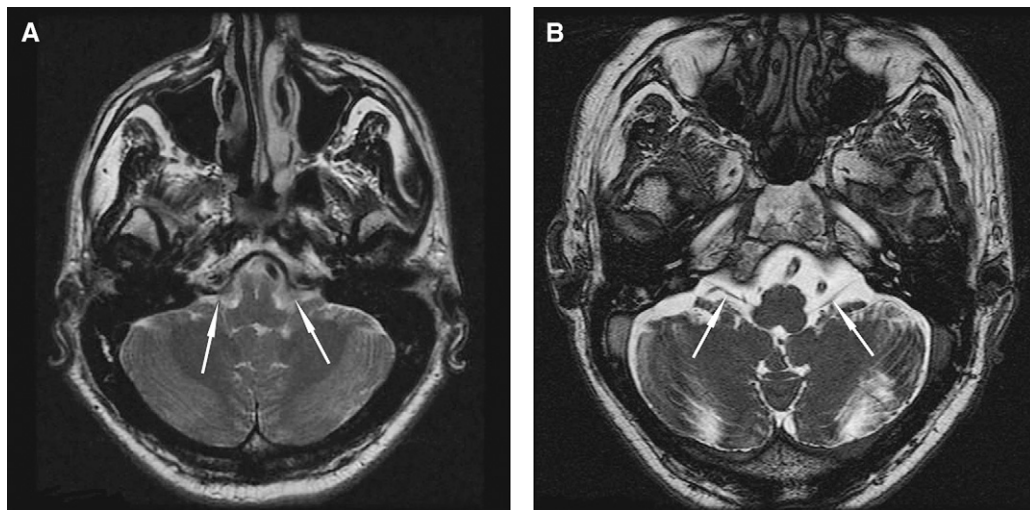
(A) Axial T2-weighted image is insufficient to demonstrate glossopharyngeal, vagus, and accessory nerves (arrows); the glossopharyngeal nerve is the easiest to identify on axial 3-dimensional fast imaging with steady state acquisition sequence (arrows). (B) It might be challenging for vagus and accessory nerves.
